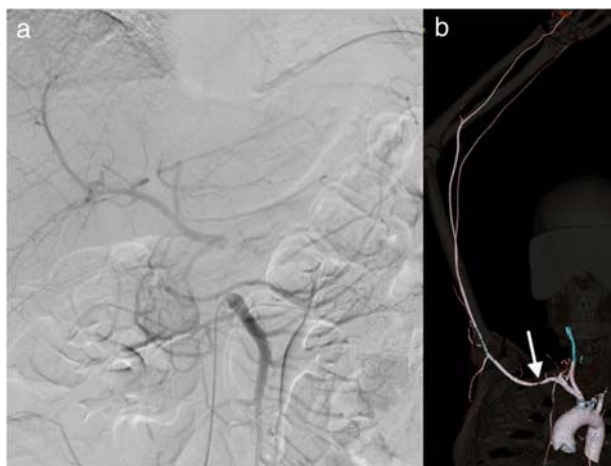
(a) Diagnostic angiogram of thrombosis of the celiac trunk and (b) CT angiography with 3D reconstruction showing stenosis of the right subclavian (white arrow).
